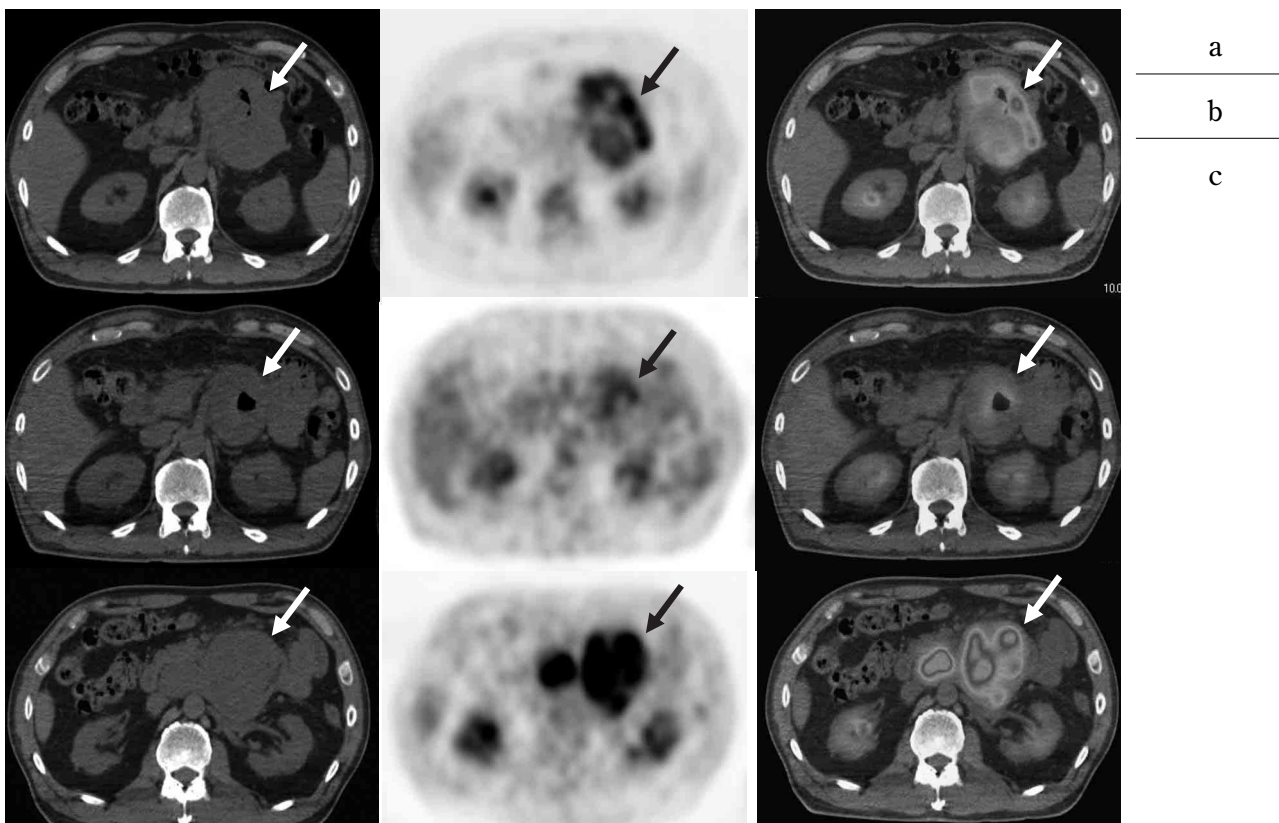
Transaxial CT (left), FDG-PET (middle), and fusion (right) images of the abdomen in a 50-year-old man with GIST categorized as high risk. The abdominal tumor showed intense FDG uptake (SUVmax 8.0) (a, arrow). Reduction in tumor size and lower FDG uptake (SUVmax 5.0) were observed on a PET/CT image (b, arrow) performed 4 months after chemotherapy with imatinib mesylate, but tumor enlargement and increased FDG uptake (SUVmax 10.0) were observed on a PET/CT image (c, arrow) performed 10 months after chemotherapy.
